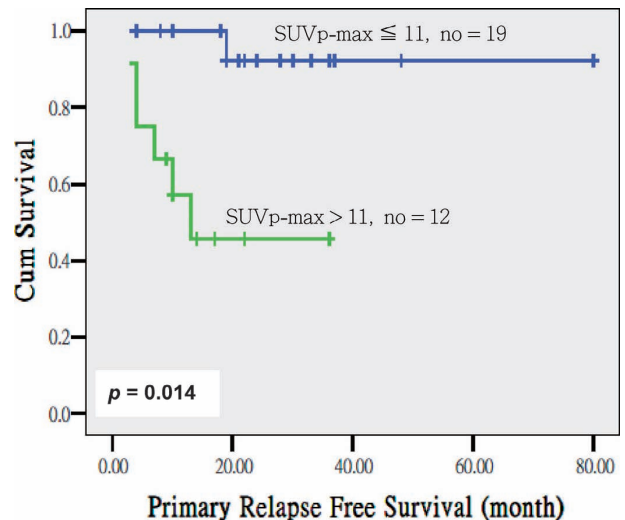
Primary relapse-free survival divided by the SUV_p-max > 11 and SUV_p-max ≤ 11 for patients with GTV_p ≤ 15.5 ml.
